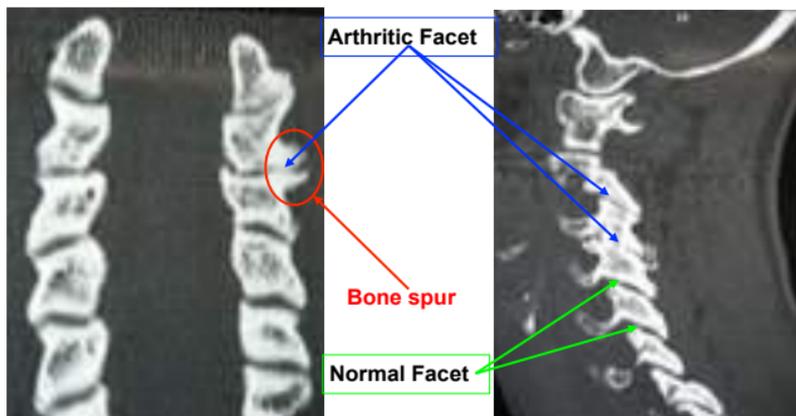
CT scan demonstrating a degenerative facet joint. *Normal* facet joints have a smooth surface made of cartilage that slides against each other. One of the facet joints is more worn out (right side of this page) than the other facet joint. This can lead to neck pain as two rough surfaces (“bone on bone”) move against each other.
